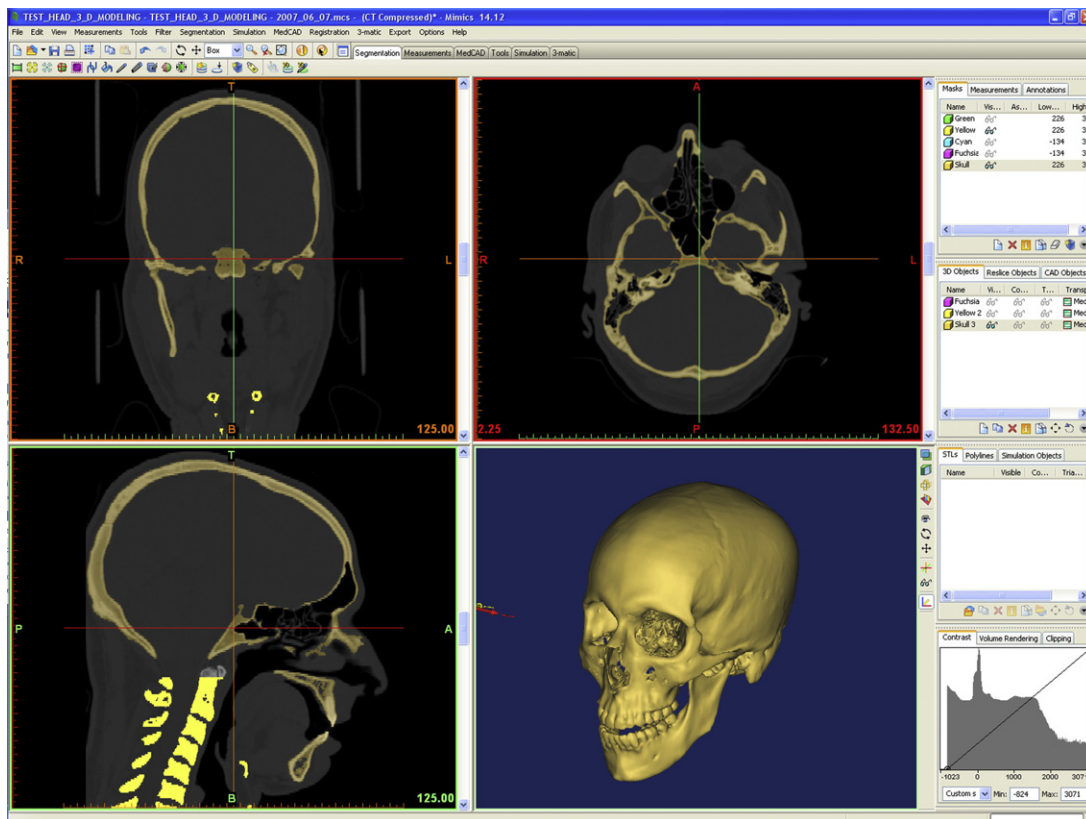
Software 3D reconstruction from CT scan.
